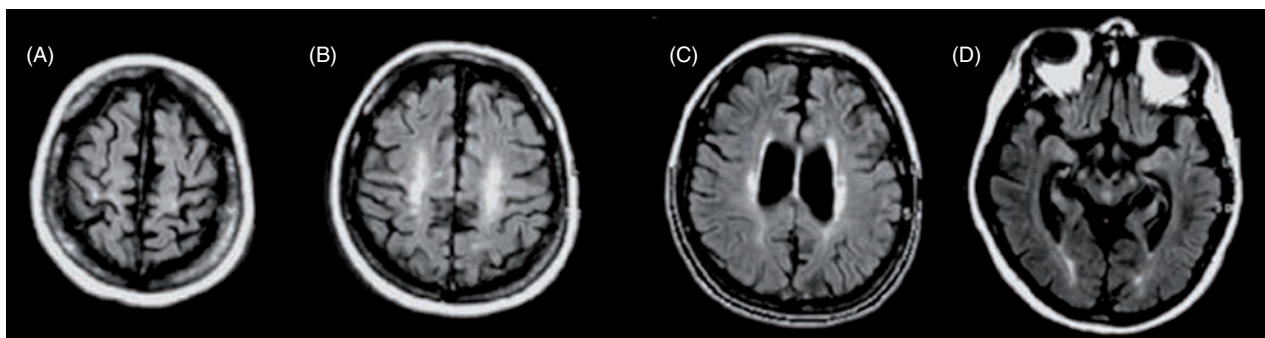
MRI of the brain of a cardiac arrest patient with excellent recovery. MRI reveals a distinct pattern of brain damage including white matter damage in three brain areas: In proximity of the primary motor and premotor cortex (A and B), periventricular white matter lesions (C), and in proximity of primary visual cortex including the optic radiation (D). *Source:* Modified from Ammermann *et al.* [144] reproduced with permission from Elsevier.
